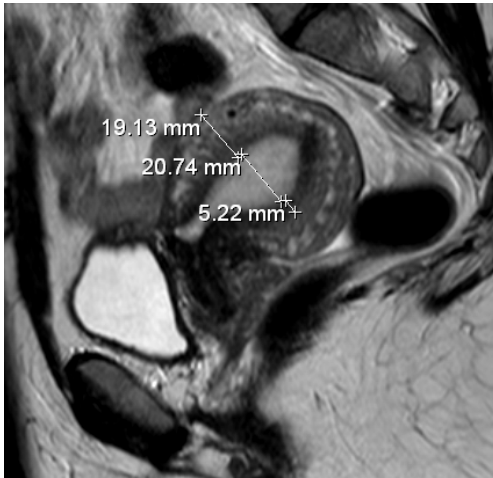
T2-weighted TSE MRI scan through the midsagittal plane of the uterus. The 20.74 mm measurement in the uterine center is obtained in the thickest part of the endometrium, from inner wall to the opposite inner wall, approximately halfway between isthmus and fundus. The 19.13 mm measurement is the thickness of the anterior wall of the corpus uteri. The 5.22 mm measurement is the thickness of the junctional zone in the posterior uterine wall.
